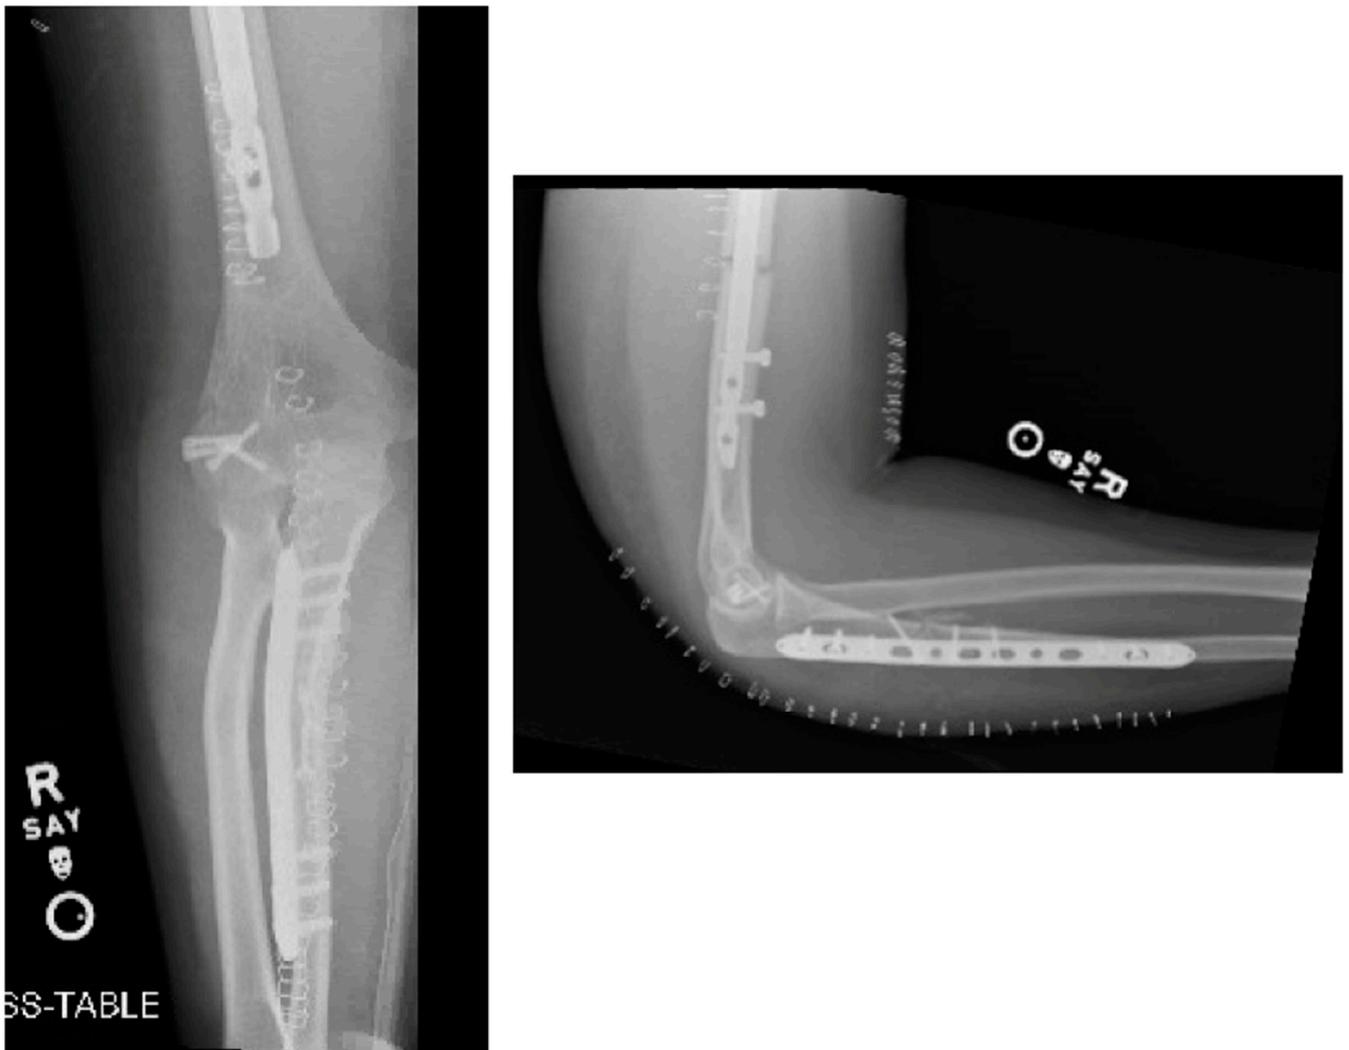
AP and lateral radiograph of right elbow demonstrating reduction and fixation postoperatively.
